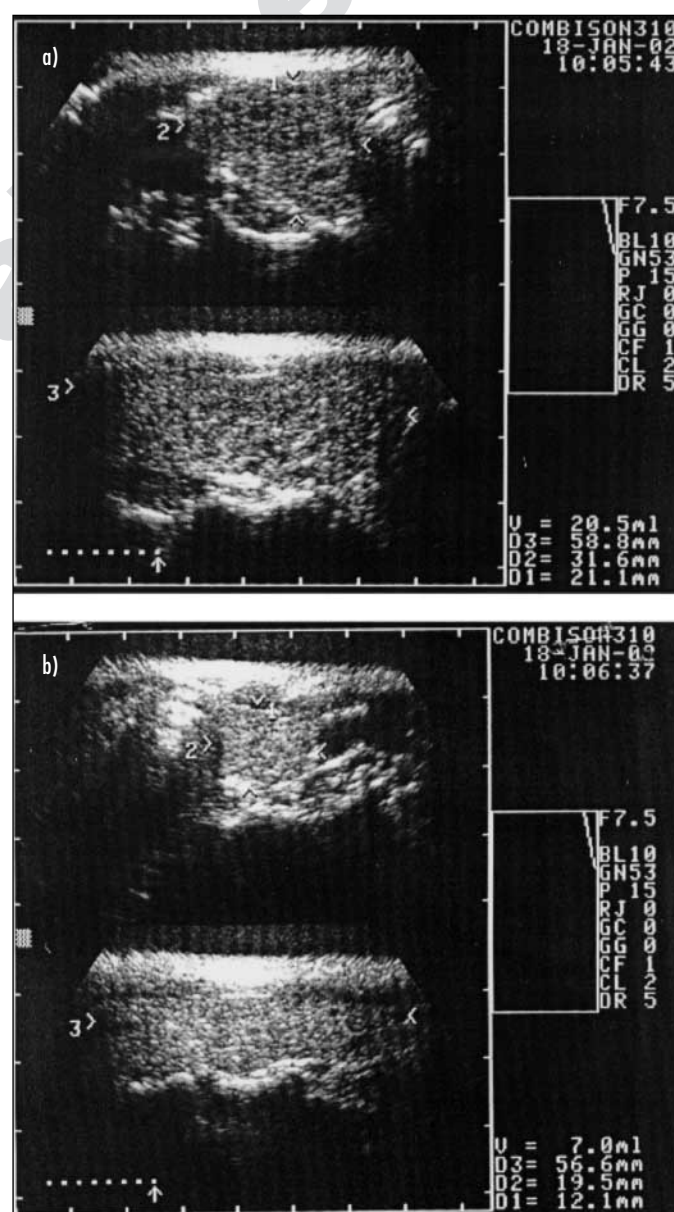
High resolution sonography of the thyroid gland. The right lobe (a) is enlarged (5.8 x 3.1 x 2.1 cm) with boundaries hardly to delineate and with increased echos distributed throughout the lobe. The left lobe (b) is normal sized (5.6 x 1.9 x 1.2 cm), showing well defined boundaries and regular echos throughout the lobe.
